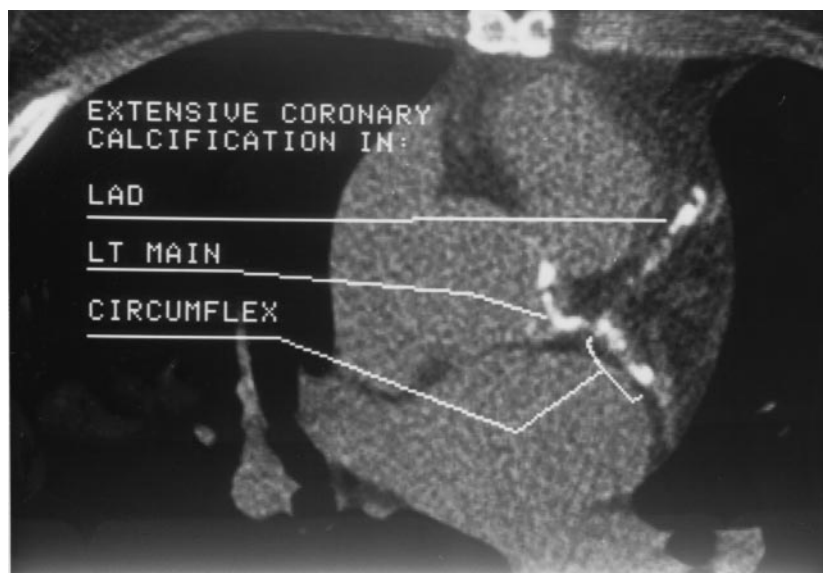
Electron beam CT coronary scan of a 48-year-old man with IC with three-vessel obstructive CAD on catheterization. Extensive calcifications of the left main, left anterior descending (LAD) and circumflex artery are seen. The total score of this patient was 1,295.
